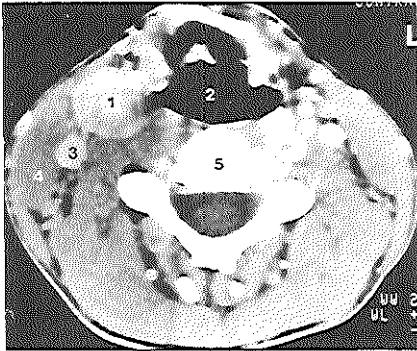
Transverse CT section after intravenous contrast medium was injected. The carotid body tumor (1) is recognized as a hyperdense structure. Air in the larynx (2); jugular vein (3); sternocleidomastoid muscle (4), and cervical vertebra (5).
